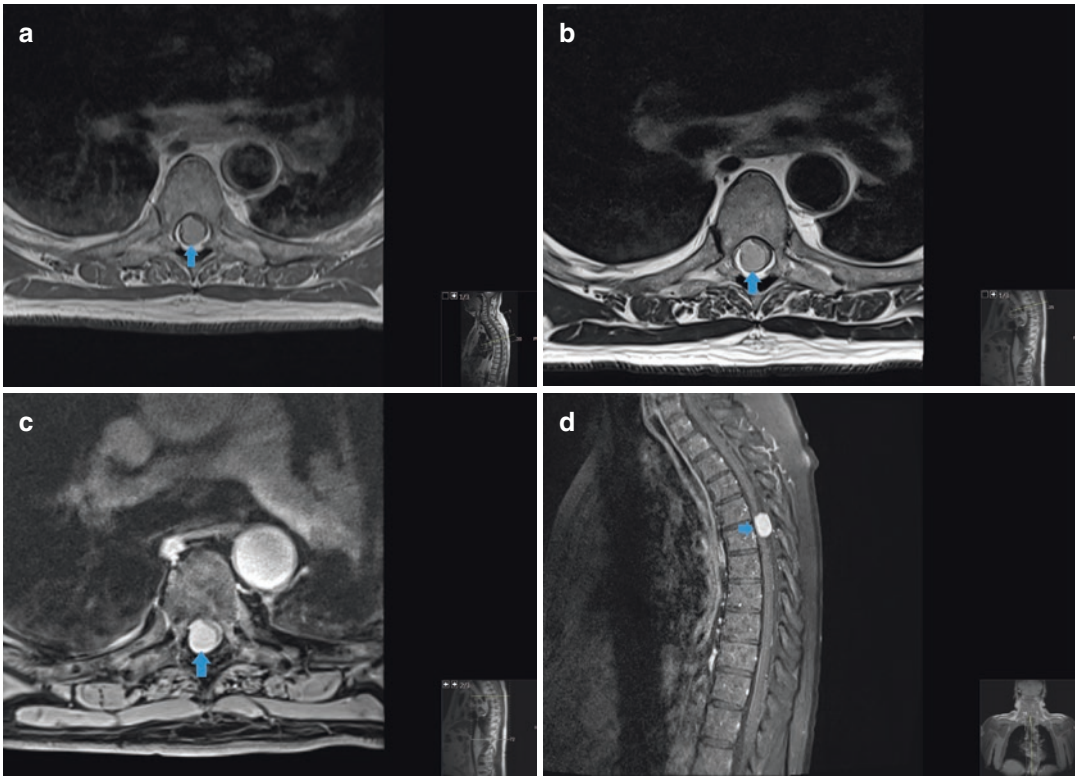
Meningioma. Figure 9.11a is an axial T1-weighted MR image showing a round isointense intradural extramedullary mass in the thoracic spine causing marked cord displacement and cord compression (arrow).
